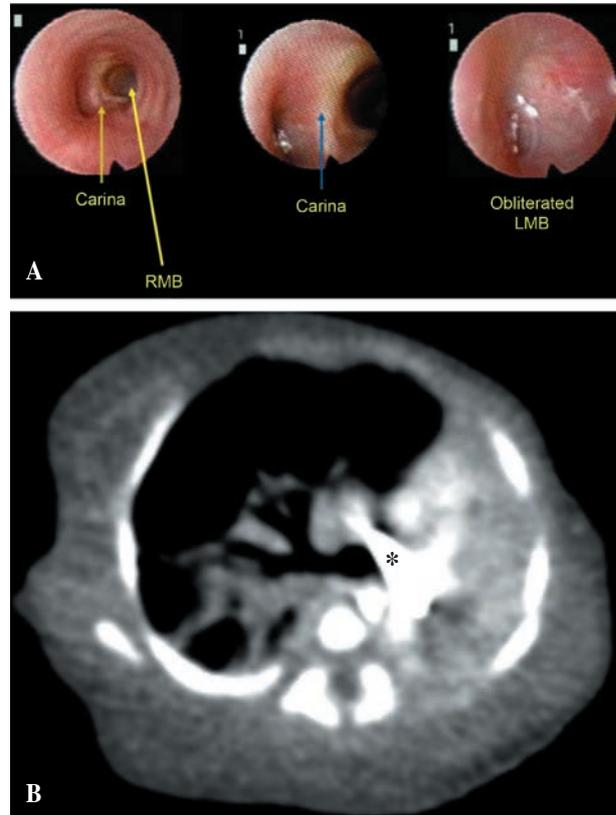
A) Left picture: FB demonstrating the trachea and the origin of the right main bronchus (RMB). Center picture: carina, RMB (partial image), and left main bronchus (LMB) without lumen. The right picture shows entire LMB collapse through the clip at the level of the ductus arteriosus. B) CT-scan demonstrating complete atelectasis of the left lung and presence of a clip obliterating the lumen of the left main bronchus at the level of the ductus (asterisk).
